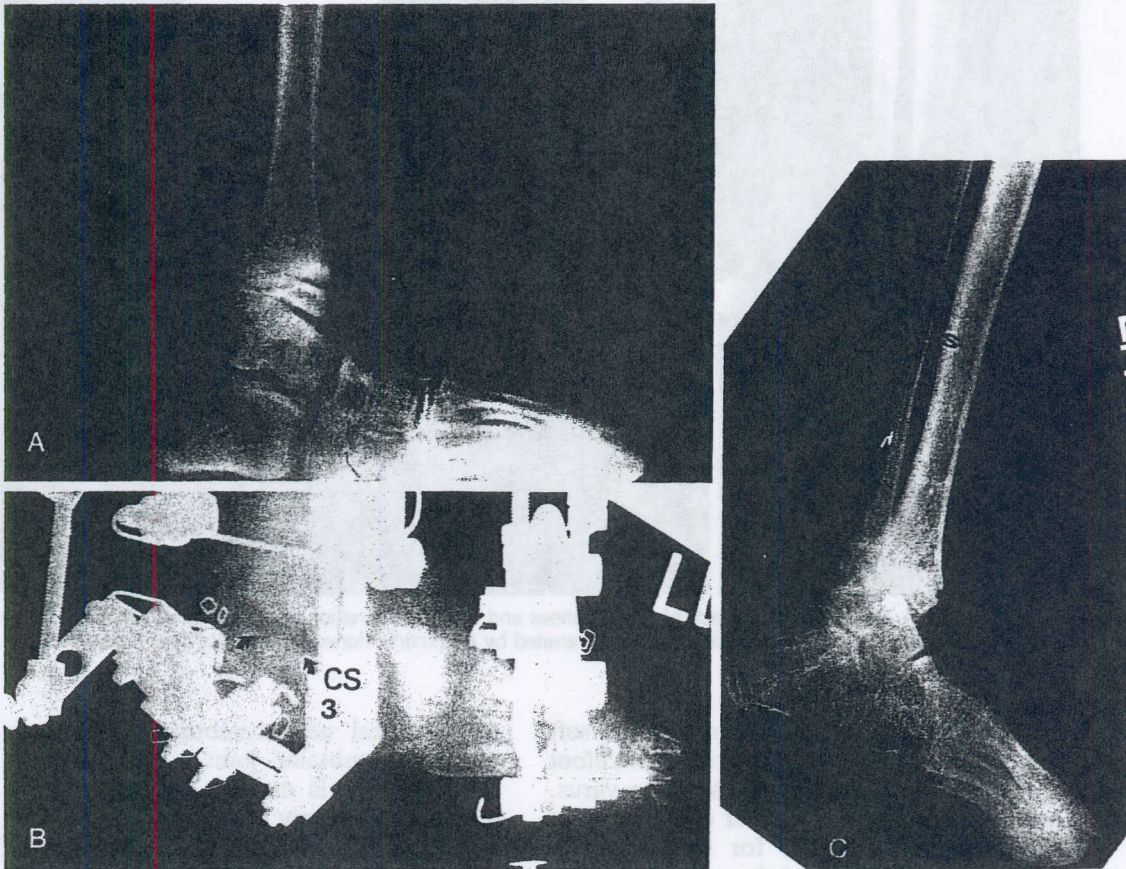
(A), Lateral radiograph of a 7-year-old girl with a varus rocker-bottom heel secondary to Streeter's syndrome. Her insensate foot was developing an area of breakdown under the prominent rocker-bottom apex. (B), A posterior calcaneal osteotomy was performed with simultaneous tibial lengthening and opening wedge correction of the calcaneal deformity. The calcaneal osteotomy prematurely consolidated due to lack of fixation of the anterior portion of the calcaneus. The path of least resistance was for distraction of the subtalar joint rather than the osteotomy. Note the diastasis of the subtalar joint (arrows). A repeated osteotomy was necessary to complete the treatment. (C), The final lateral radiograph demonstrates a plantigrade appearance to the plantar aspect of the foot. The heel ulcer promptly healed. (Courtesy of Dror Paley, M.D.)
